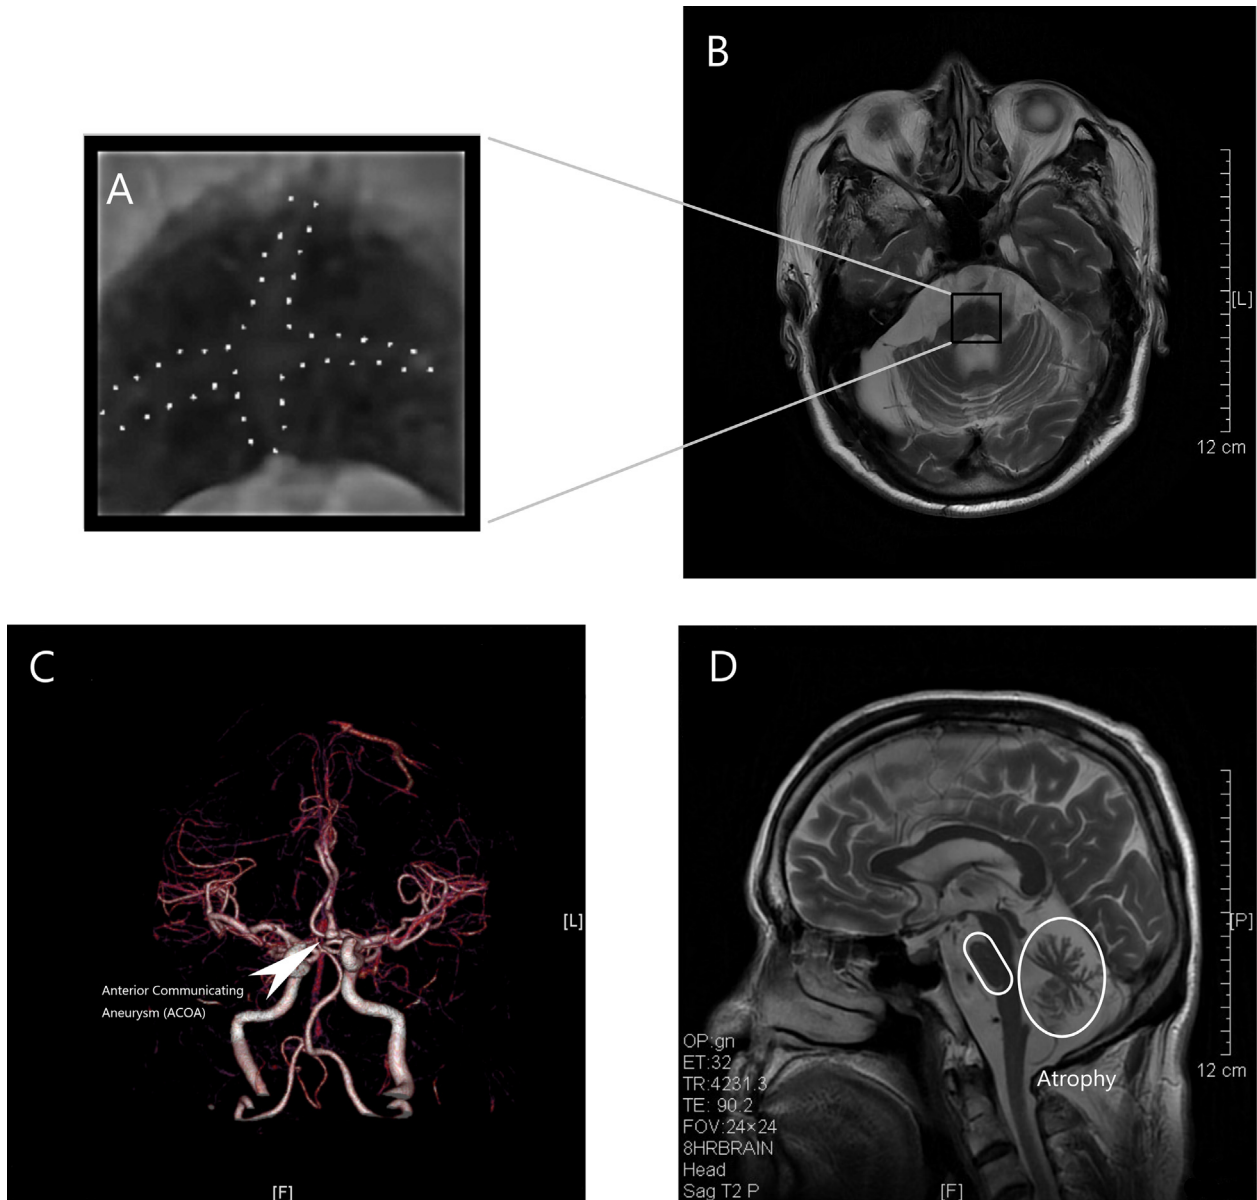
Head MR+CTA examination indications: The “hot cross bun sign” can be seen in mesocephalon (A and B). There was arterial aneurysm in anterior communicating artery (C). Mesocephalon and epencephalon exist atrophy obviously (D).
